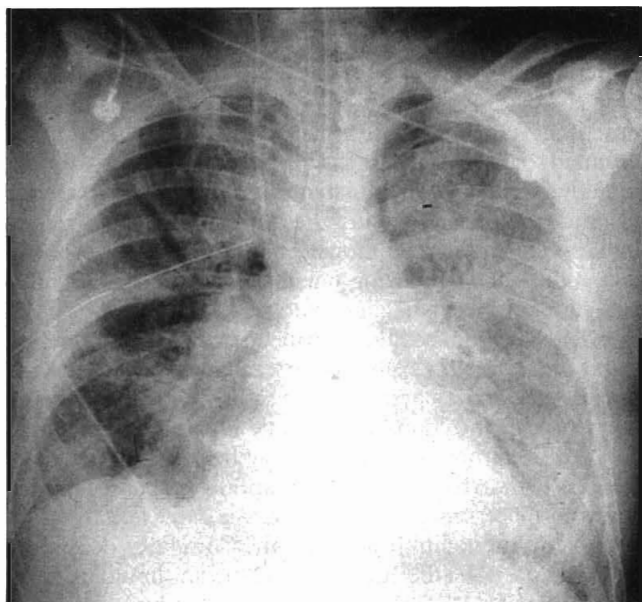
Portable anteroposterior chest radiograph from a patient with early acute respiratory distress syndrome. Note the diffuse bilateral infiltrates, normal heart size, endotracheal intubation, and the presence of a right-sided thoracostomy tube for drainage of pneumothorax.
